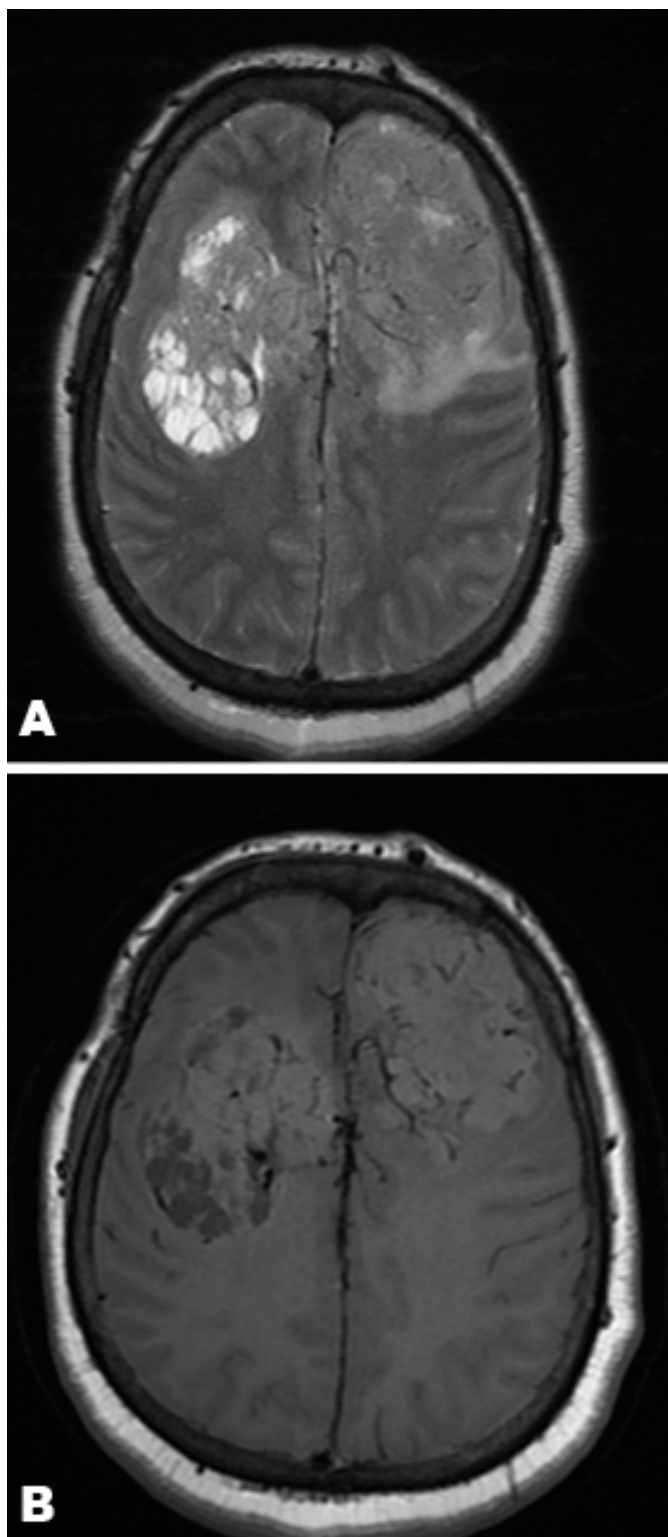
(A) Axial T1-weighted and (B) Axial T2-weighted magnetic resonance imaging scan revealing a lobulated mass with a central necrotic component showing heterogeneous low signal on T2-weighted images and an iso-low signal on T1-weighted images with signal voids suspected to be a vascular structure.
